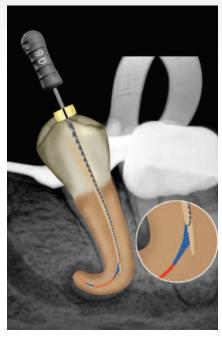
A size 08 C+ File (18 mm) with a distinct curve in the apical 2-3 mm of the file was selected to try and bypass the ledge.
